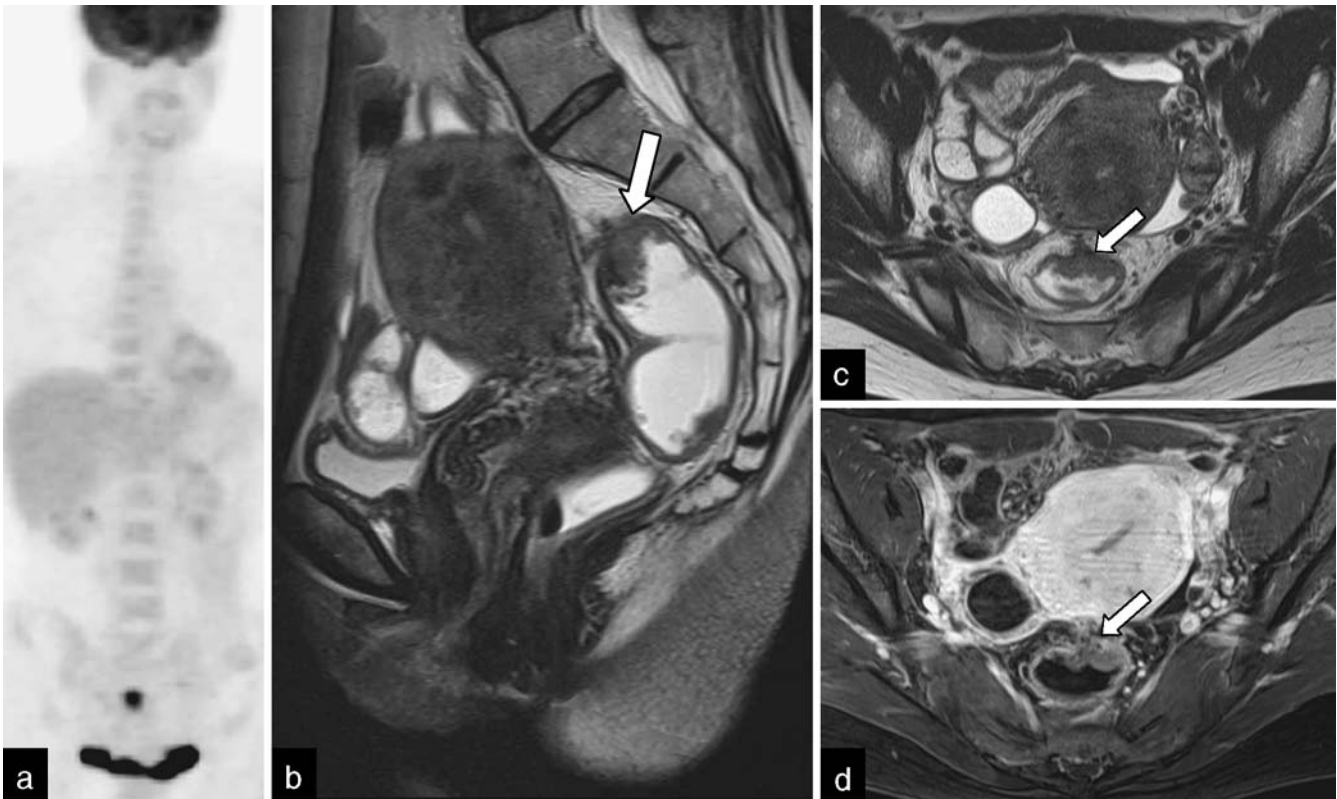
Staging of a female 3 months following tumor perforation of the sigmoid and Hartmann procedure. a PET image shows a focal FDG uptake in the presacral area, suggesting residual tumor. The corresponding MRI confirmed the diagnosis (b, c, d). b The
